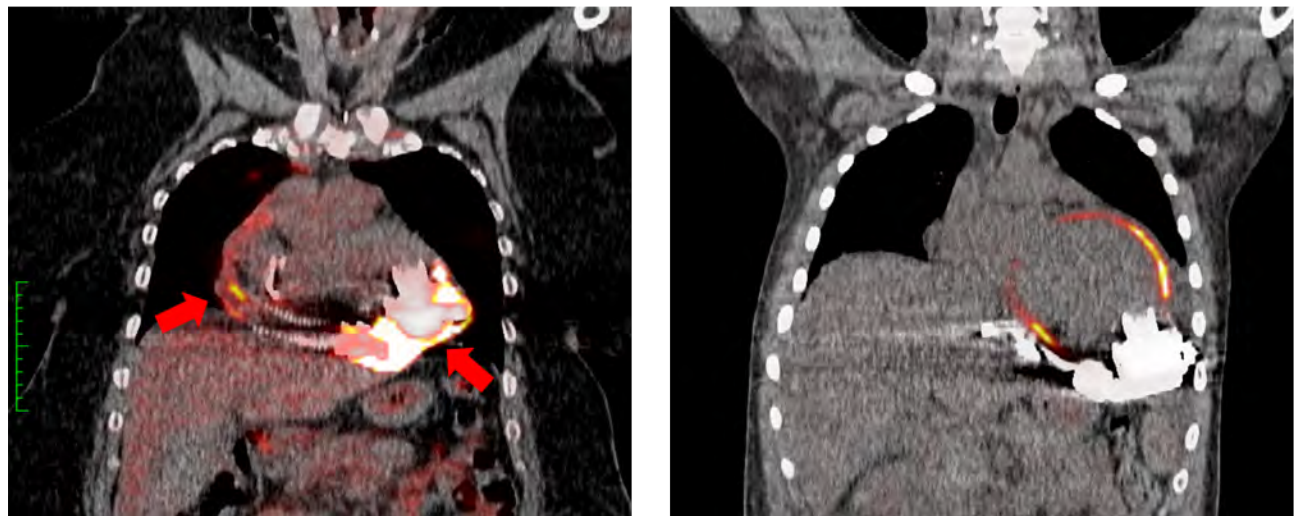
Left panel shows fused  $^{18}\text{F}$ -FDG PET/CT imaging with increased FDG uptake corresponding to the LVAD pump and cannula (red arrows). Right panel shows fused  $^{18}\text{F}$ -FDG PET/CT imaging with no FDG uptake around the LVAD pump or cannula; diffuse (non-specific) myocardial uptake is observed.
